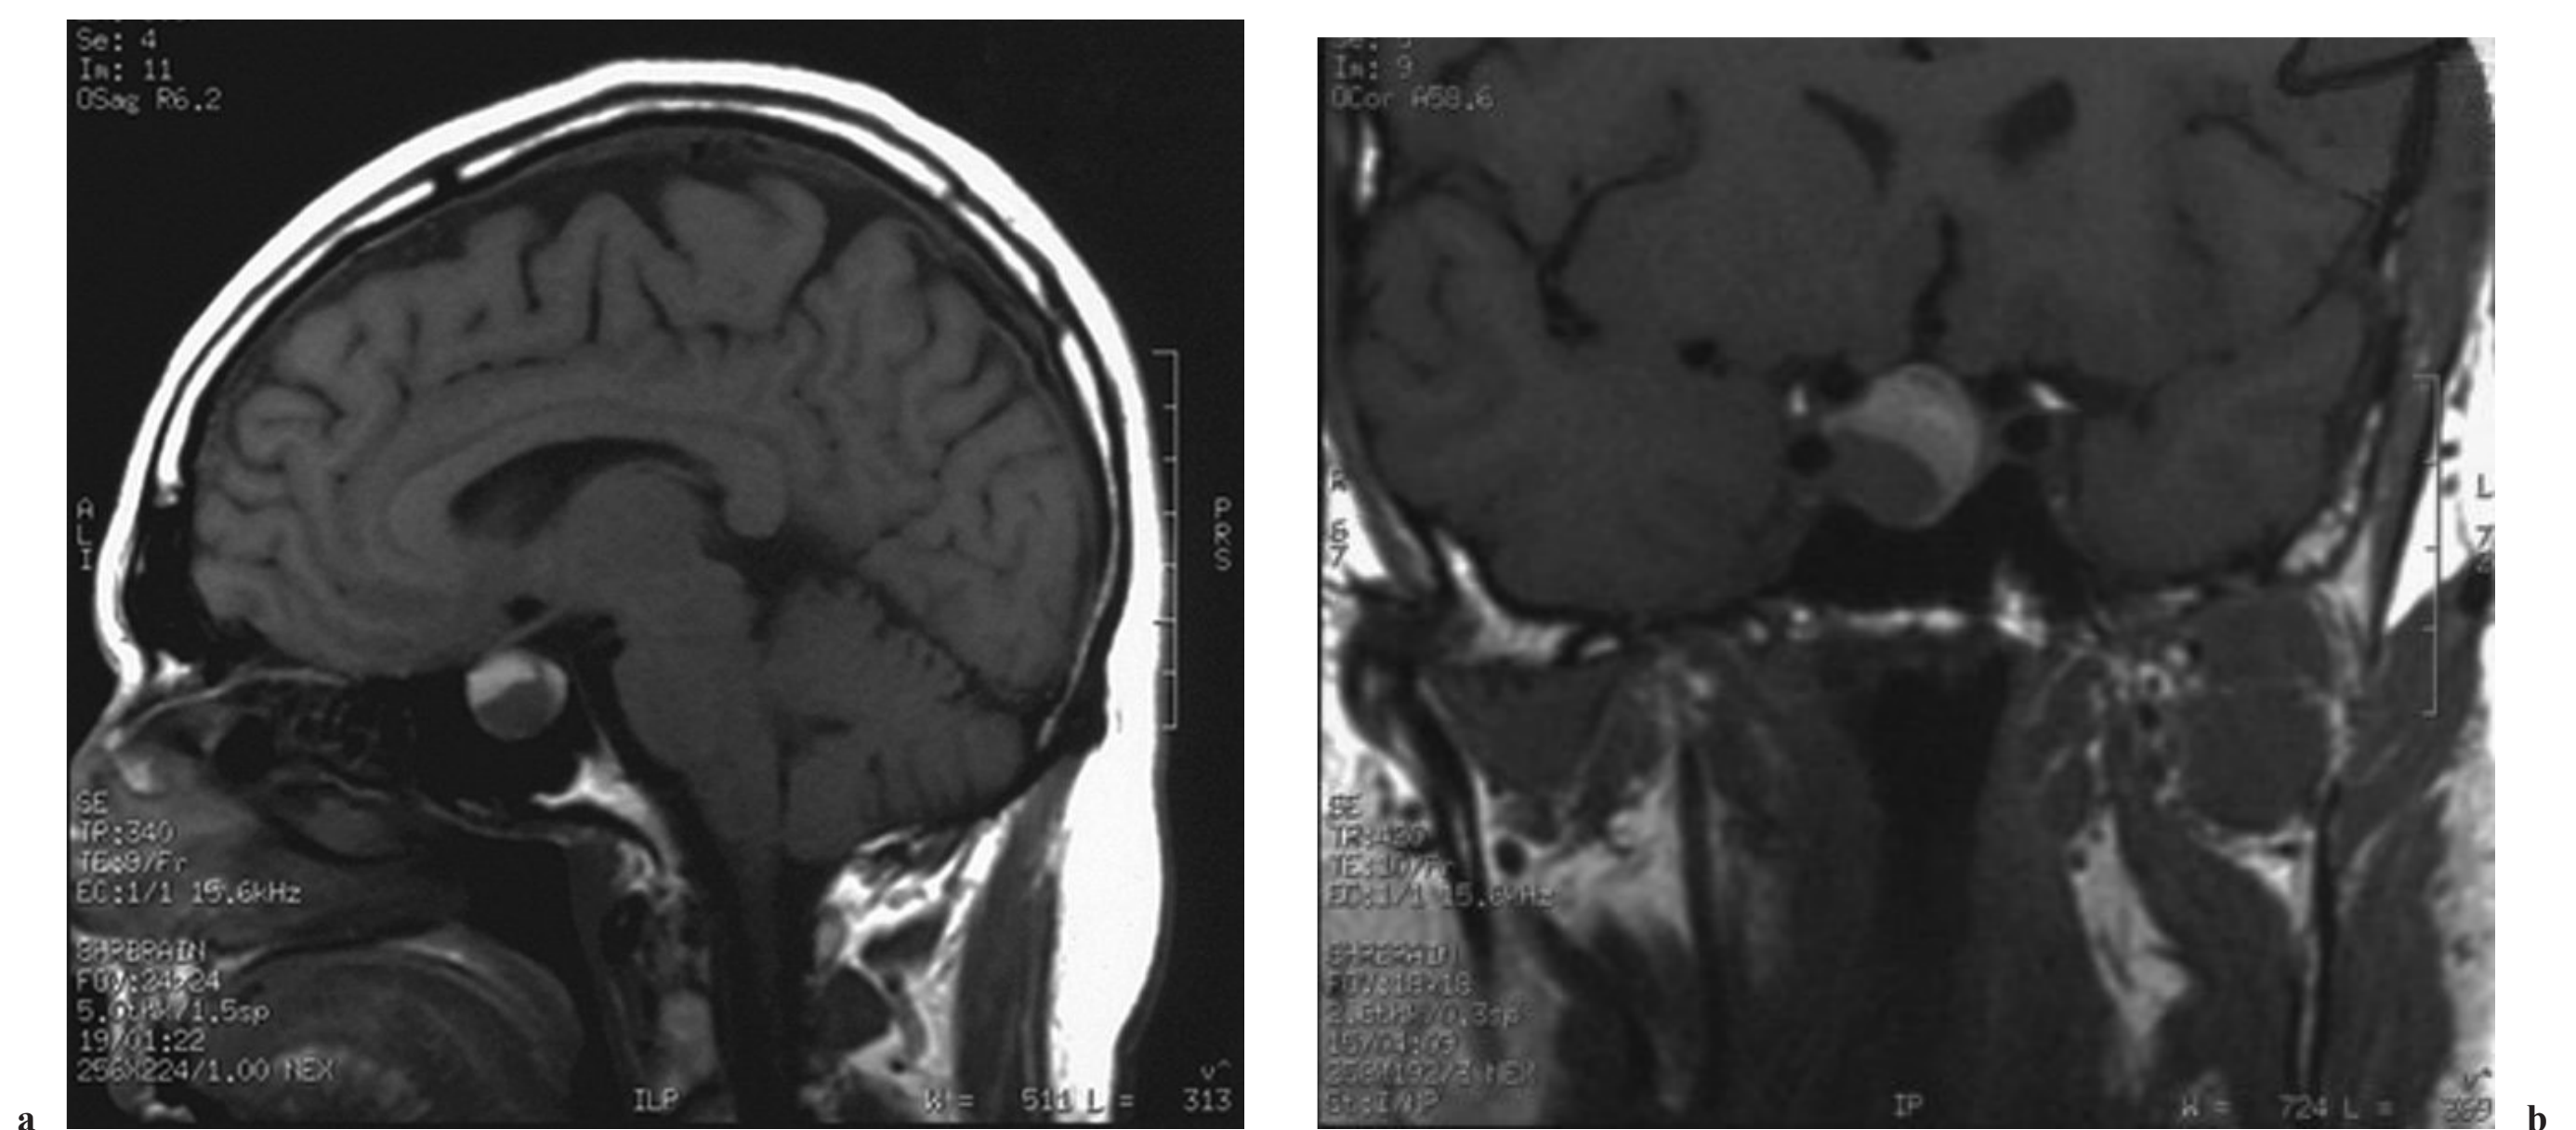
b (a) T1-weighted sagittal and (b) coronal MRI demonstrating a sellar mass of heterogeneous signal intensity, with suprasellar extension of increased signal intensity consistent with acute hemorrhage.
